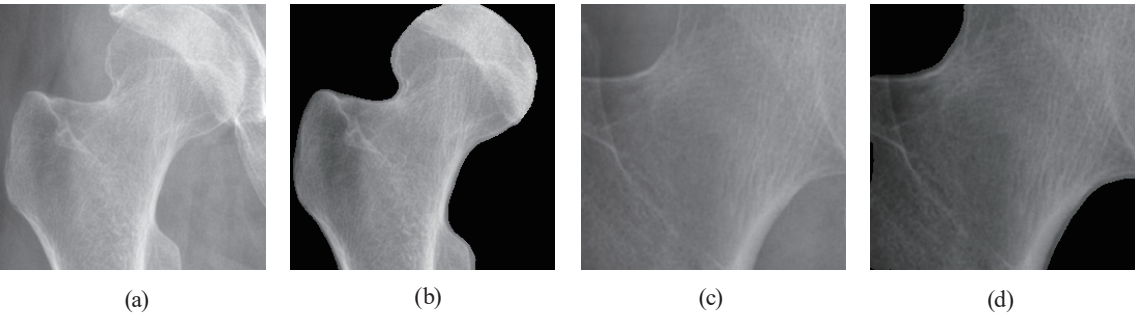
Overview of the four training datasets derived from sensor-based X-ray images: (a) original whole hip, (b) segmented whole hip, (c) original femoral neck, and (d) segmented femoral neck.
